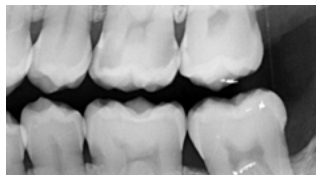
Preoperative X-ray image
